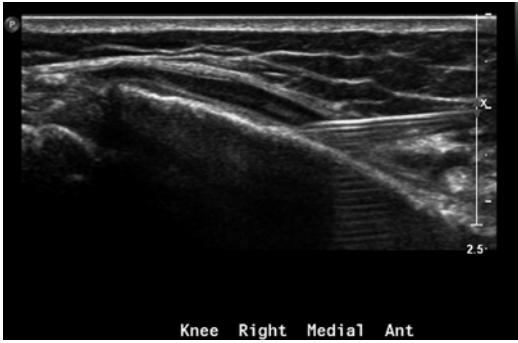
Ultrasound guided injection bursa under the pes anserinus, on the right above needle is injecting corticosteroid to the front of the anteromedial tibia
